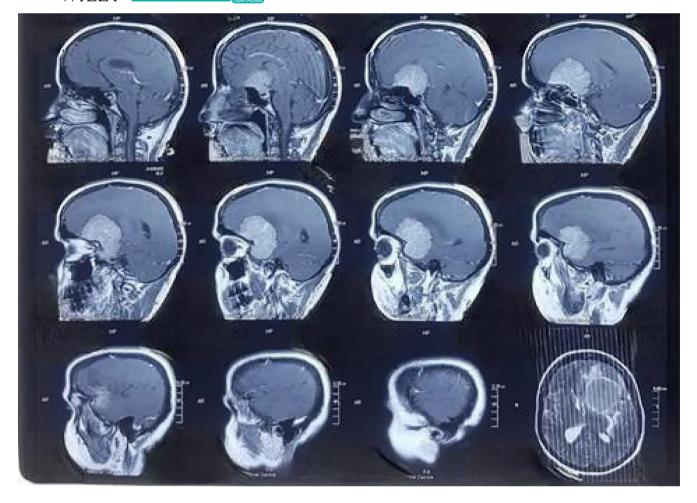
Preoperative sagittal magnetic resonance imaging brain of the patient.
